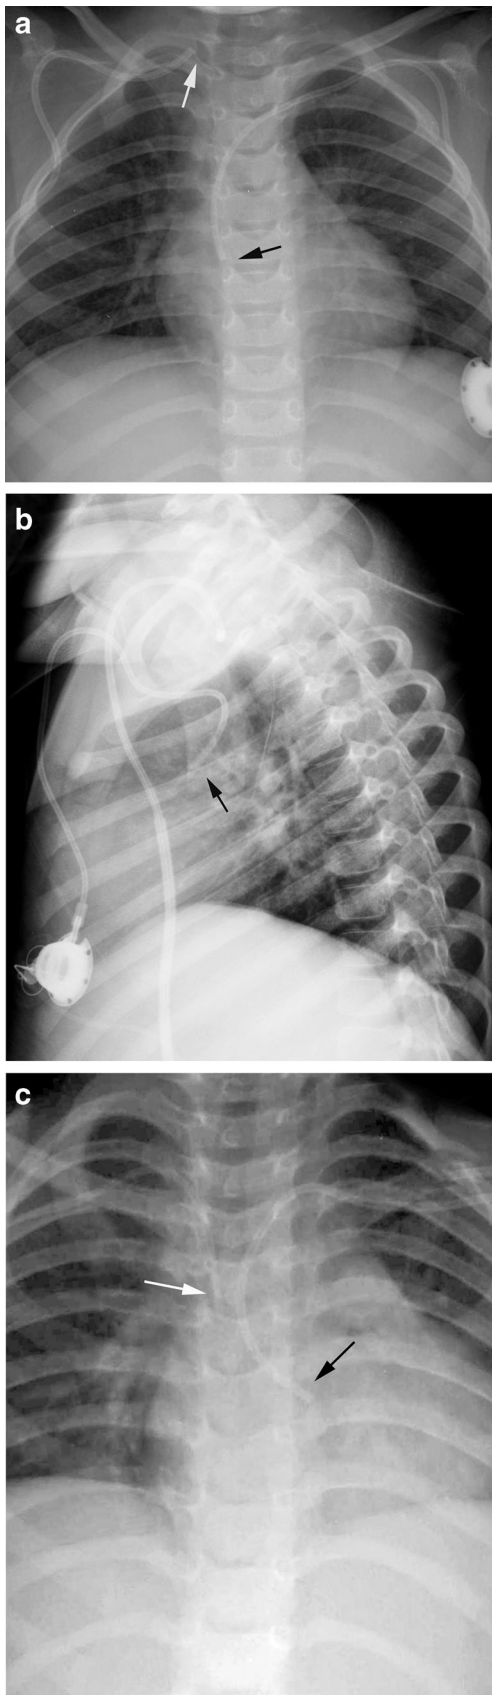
Case 4, a 3-year-old girl with acute lymphocytic leukemia. a Anteroposterior (AP) chest radiograph shows a right subclavian venous catheter inserted via a right subclavian approach, with its tip in right subclavian vein (*white arrow*). An aortic catheter inserted via a left subclavian approach (*black arrow*) shows subtle leftward curvature of the catheter, with the catheter tip overlying the right lateral border of the thoracic spine. b Lateral chest radiograph shows exaggerated anterior angulation of the arterial catheter (*arrow*). c AP chest radiograph obtained several days later shows a normally placed venous catheter (*white arrow*) and an arterially placed catheter in the ascending aorta (*black arrow*). Note that the catheters do not cross, and there is an exaggerated leftward angulation of the arterial catheter, with tip position to left of the thoracic spine
